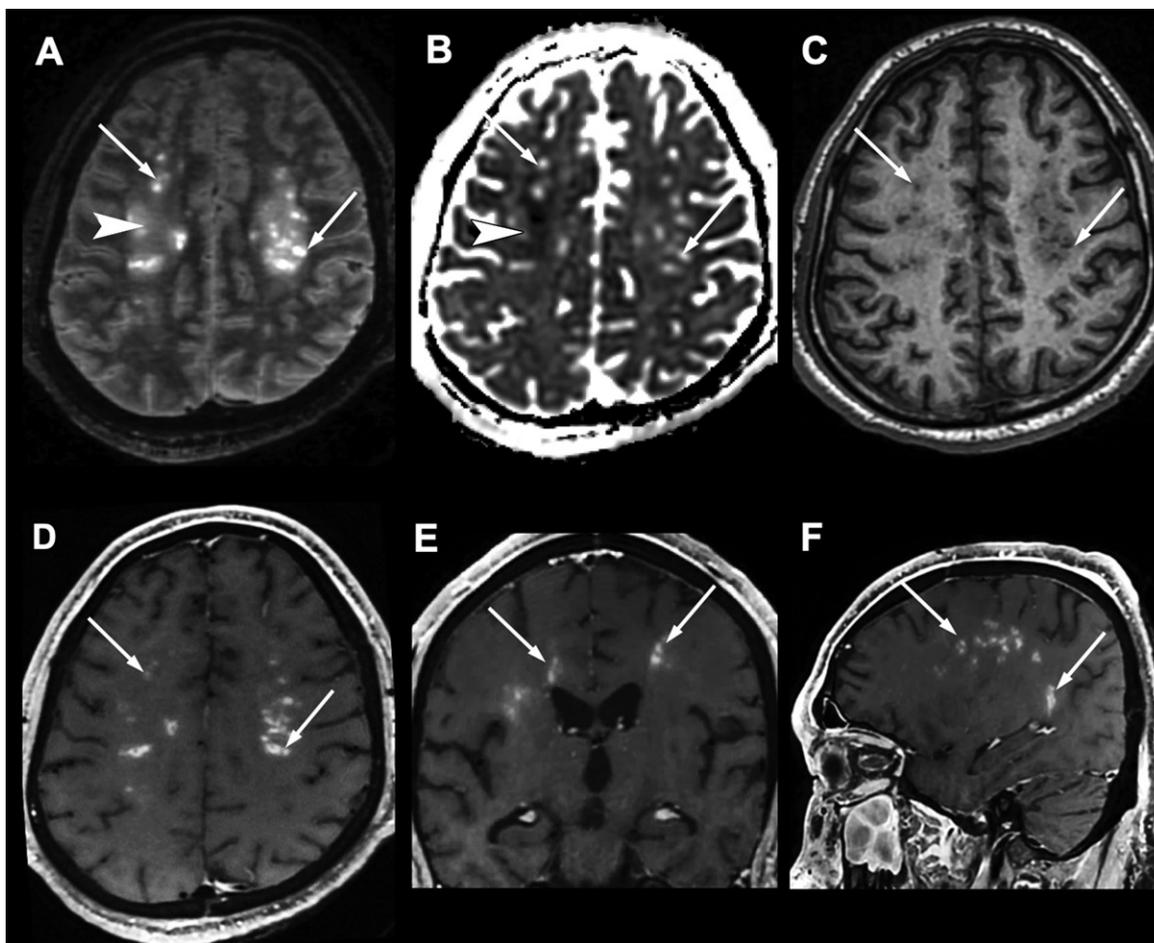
White matter–enhancing lesions in a 37-year-old obese man with no relevant medical history who was admitted to the intensive care unit for severe acute respiratory syndrome coronavirus 2–associated pneumonia 10 days after the onset of flulike symptoms. He developed severe acute respiratory syndrome, recurrent venous thromboembolism with negative thrombophilia test results, and multiorgan failure. MRI was performed for late awakening after withdrawal of sedation after 38 days of intensive care. The patient did not recover consciousness and died 42 days after brain MRI. There were symmetrical multifocal periventricular and deep white matter lesions that were hyperintense on axial fluid-attenuated inversion recovery (FLAIR) images, *A*, with a vacuolated appearance (arrows), *B*, without diffusion restriction (arrows), *C*, that were hypointense on T1-weighted images (arrows), *D–F*, and with perivascular enhancement on postcontrast T1-weighted images (arrows). These lesions were associated with white matter FLAIR hyperintensities (arrowhead in *A*) with decreased apparent coefficient diffusion (arrowhead in *B*).
